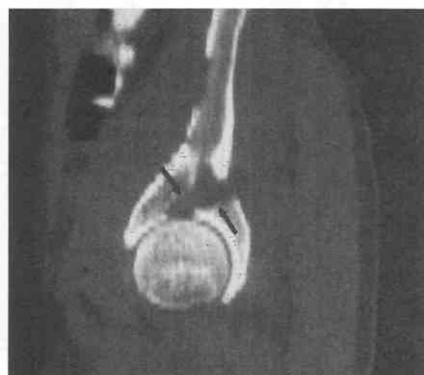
The patient is a 25-year-old man who sustained a transverse acetabular fracture in an automobile accident. Sagittal CT reconstruction shows the axially oriented fracture (*arrows*) involving both columns at the level of the acetabular roof, dividing the innominate bone into superior and inferior fragments.
